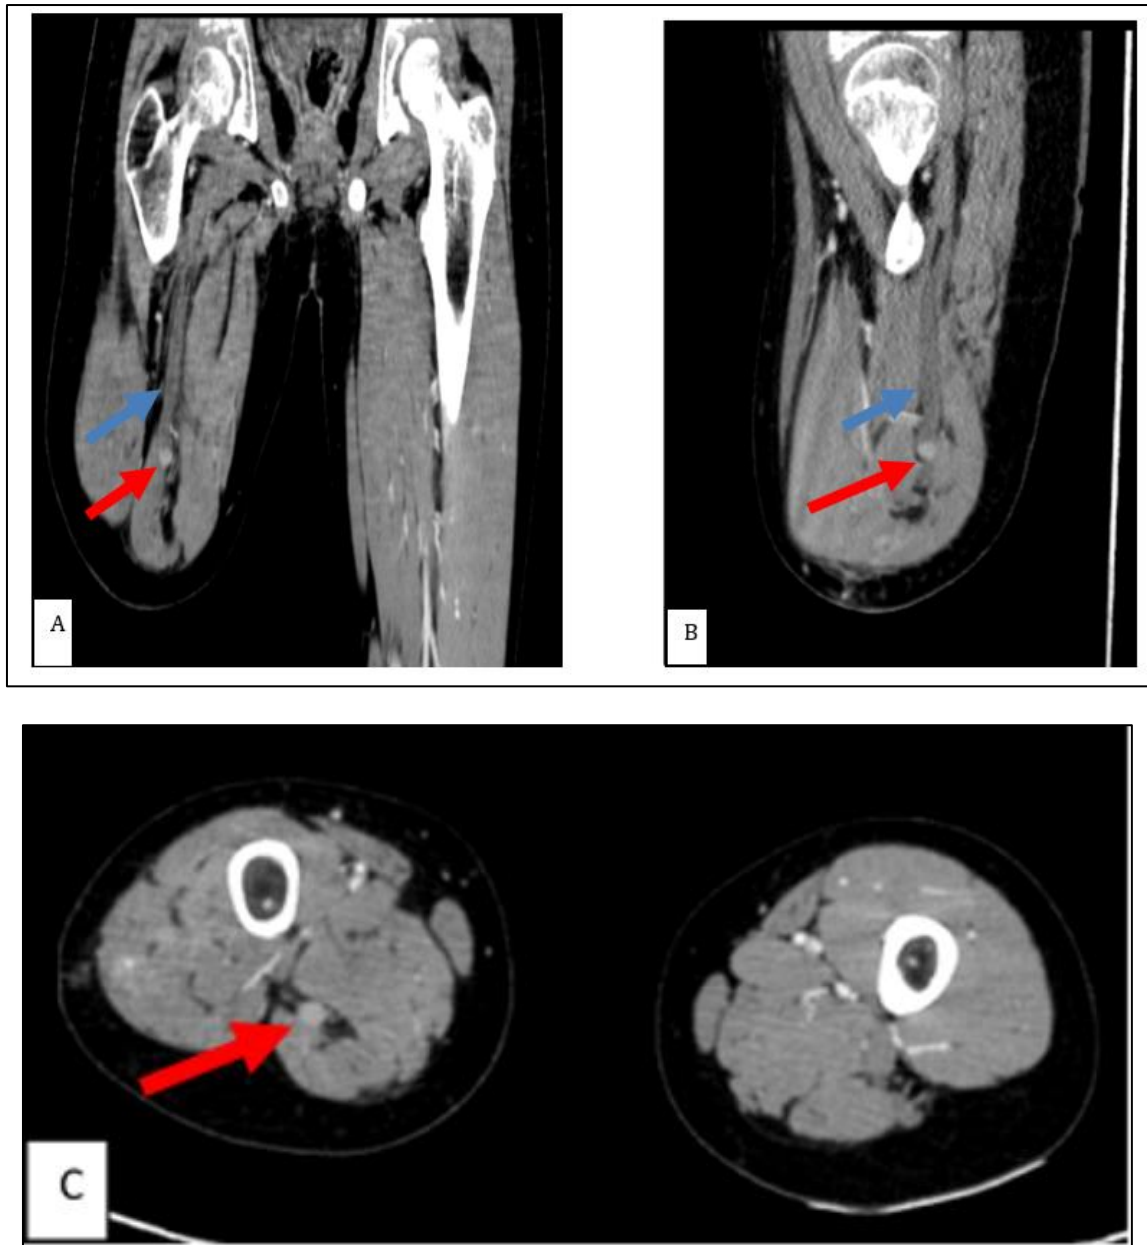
Coronal (A), sagittal (B), and axial (C) contrast-enhanced CT images obtained during postoperative pre-chemotherapy evaluation show a small soft-tissue lesion in the posterior compartment of the right thigh, in continuity with the transected sciatic nerve stump (blue arrow), a few centimetres proximal to the amputation stump, with homogeneous enhancement (red arrow)
